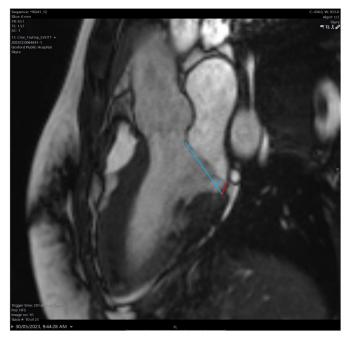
Parasternal long axis sequence, cardiac MRI. Longitudinal MAD distance of 6 mm (red line), with 5 mm atrial excursion of mitral annulus (blue lines).
